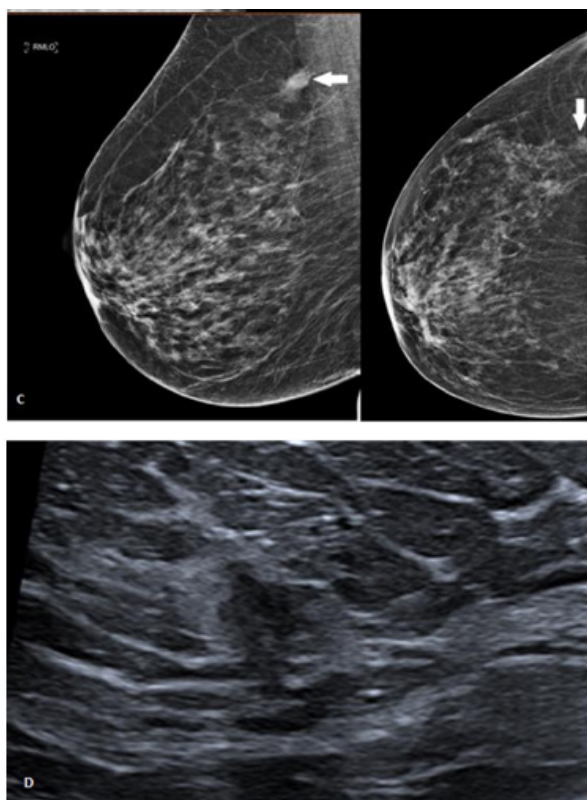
A. Follow-up contrast-enhanced chest CT in a patient with lung carcinoma shows an incidental right breast lesion with contrast enhancement up to 102 HU. B. Same image with smaller FOV (field-of-view) evidencing the spiculated and irregular borders. C. Digital mammography of the same patient showing an irregular lesion with blurred borders. D. Ultrasound imaging reveals a hypoechoic lesion with angulated borders associated with a hyperechoic halo.
